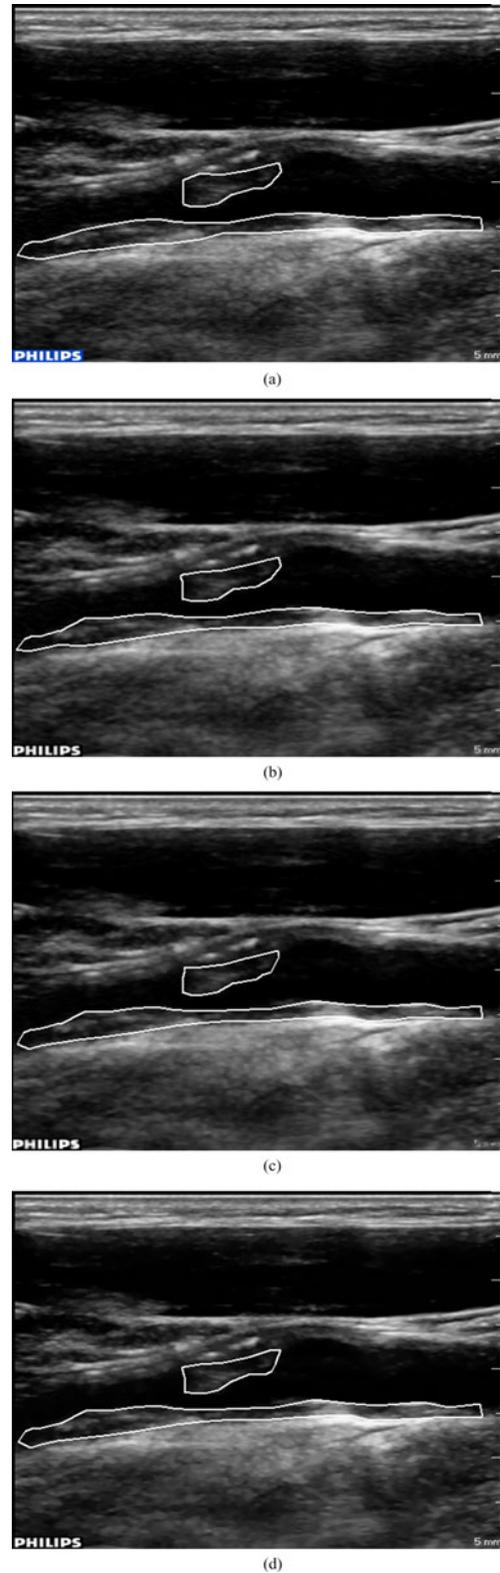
Original and despeckled ultrasound images examples. Near and far wall atherosclerotic plaque segmentation (outlined by the white lines) using the segmentation algorithm described in [30]. (a) Original, (b) DsFlsmv, (c) DsFhmedian, and (d) DsFsrad. Note that the subtle differences between the despeckled and original image are difficult to detect which indicates that the moderate amount of despeckling used here removes higher frequencies that are not easily detected by the HVS (as desired). They become visible when the clinicians zoom into the regions of interest.
